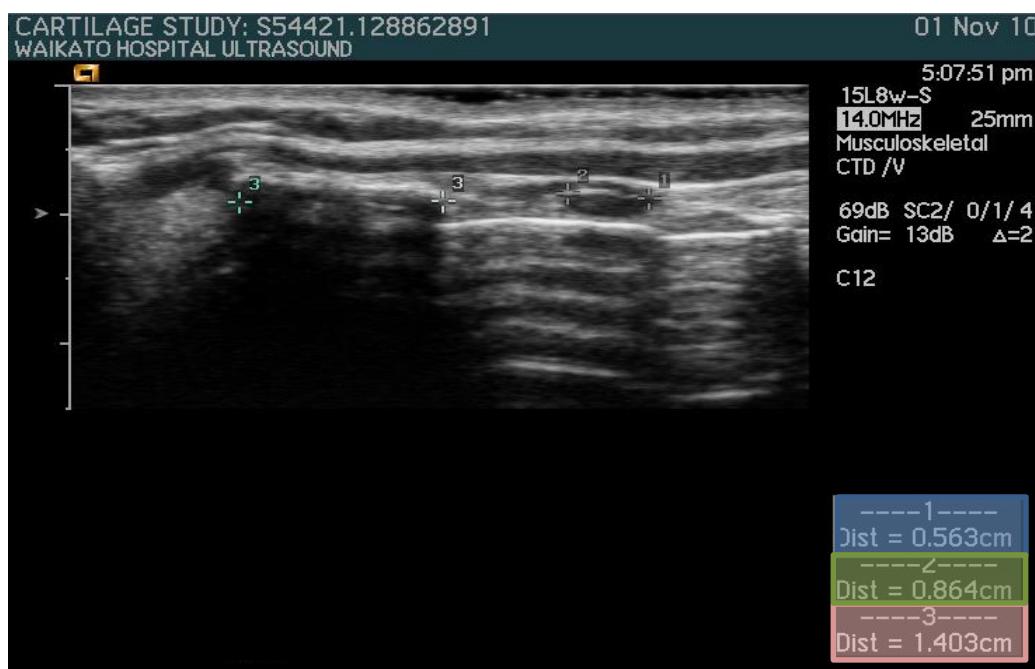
Longitudinal sagittal ultrasound image of larynx with measurements.
